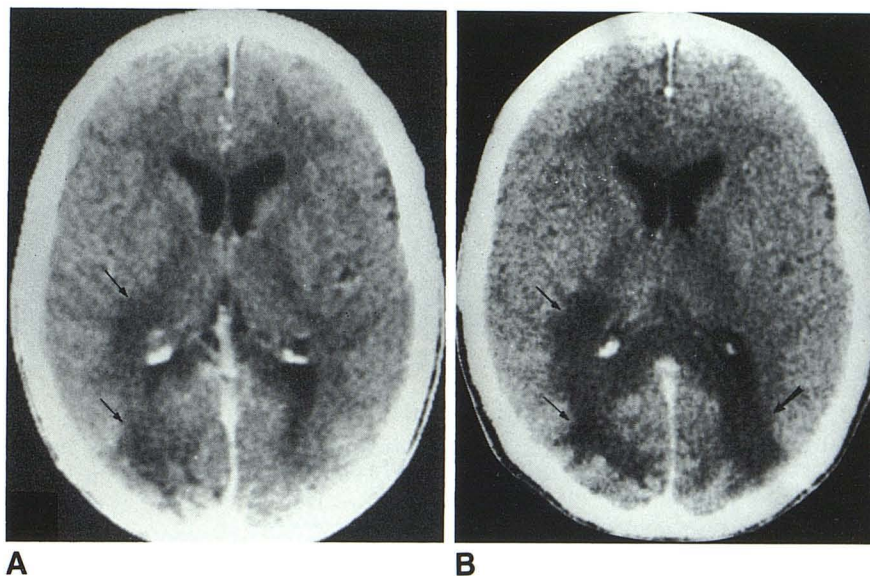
A, Contrast-enhanced CT scan. Low density in right periventricular white matter (*arrows*) without significant mass effect. B, 3 weeks later. Bilateral hypodense periventricular lesions (*arrows*) were found at biopsy to represent PML.
